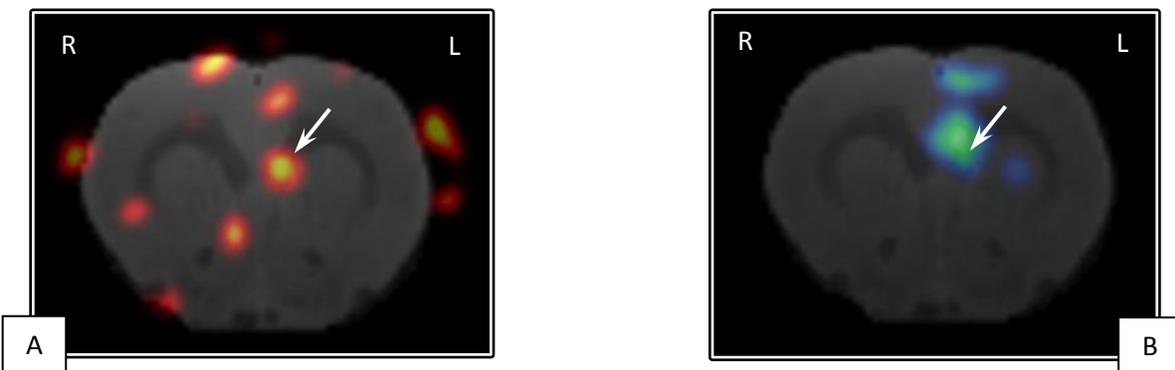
PET-FDG image of prelimbic region.
